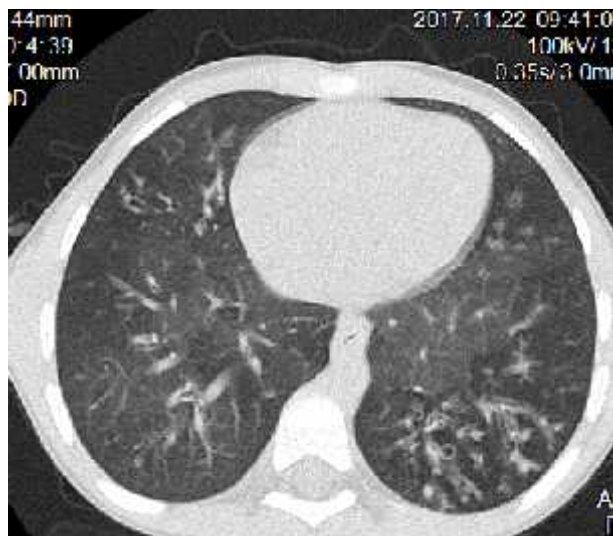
F508del/W1282X*. CT of the thoracic cavity (22.11.2017) cylindrical and varicose bronchiectasis in S₁, S₂, S₄, S₅, S₆ of the right lung and in S₅, S₉, S₁₀ of the left lung. Minimal left pleural effusion..
